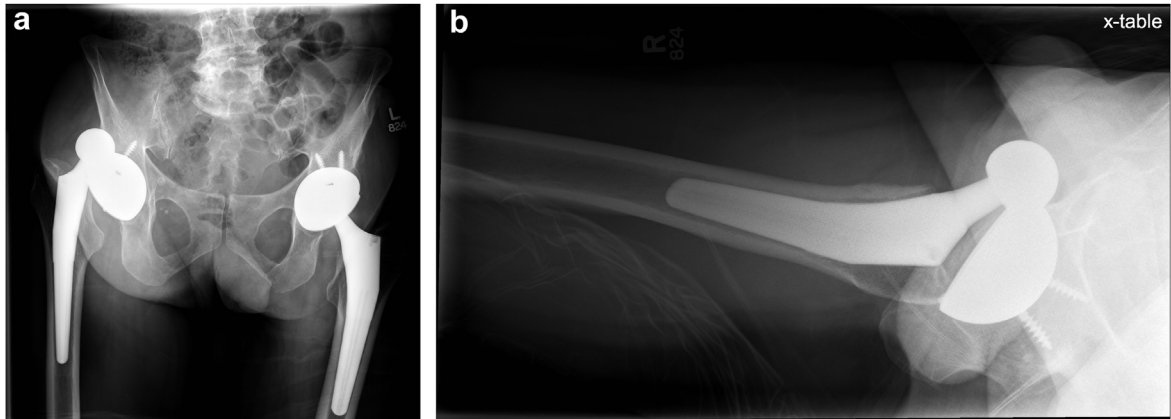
Anteroposterior (AP) pelvis (a) and direct lateral (b) radiographs of a patient with a dislocated right THA. Again, the anterior direction of dislocation is only visible on the direct lateral view.
